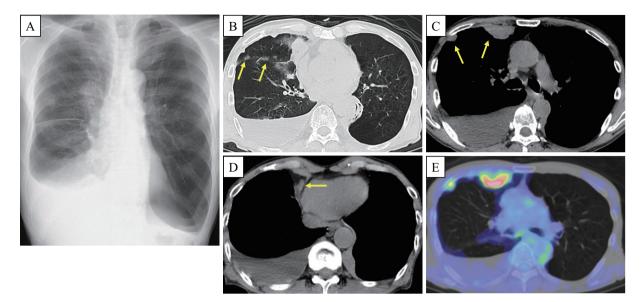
Radiological findings of malignant pleural mesothelioma. A: Chest X-ray. X-ray showing multiple nodular shadows and pleural effusion on the right side. B: Chest CT of the lung window. CT reveals multiple tumor shadows (yellow arrows) on the interlobar pleura on the right side. C: Chest CT of the mediastinal window. CT shows multiple pleural mass shadows (yellow arrows) and right pleural effusion. D: Chest CT of the mediastinal window. The nodule had infiltrated into the mediastinal fat tissue (yellow arrow). E: PET-CT reveals the accumulation of FDG in the right pleural mass.
